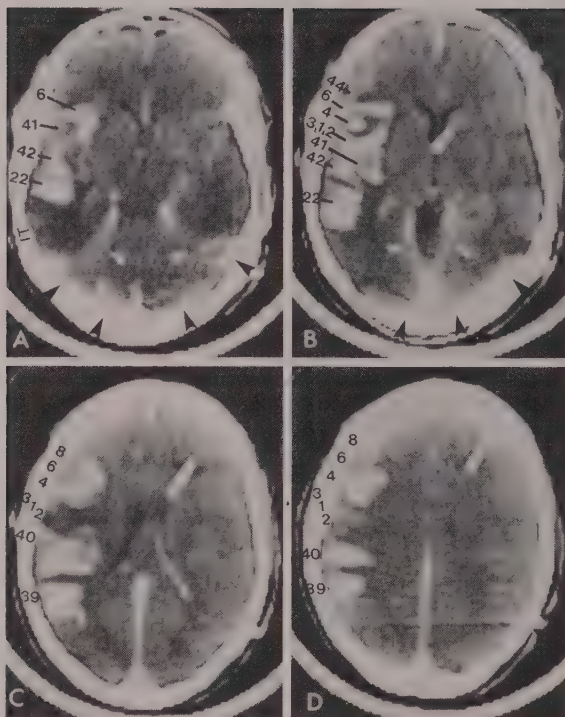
Infarction of the left cerebrum. CT localization to specific Brodmann areas. CECT scans in a 40 year old woman with severe left middle cerebral artery spasm and prolongation of the left arteriovenous circulation time to 10.0 seconds after subarachnoid hemorrhage, clipping of a left posterior communicating artery aneurysm, and insertion of a ventriculoperitoneal shunt for hydrocephalus. The gyral blush associated with the cerebral ischemia delineates the gyral anatomy corresponding to the Brodmann areas (see Figs. 2B and 3). A, CECT scan along reference line 3 reveals gyral contrast enhancement in Brodmann areas 6, 41, 42, and 22 with edema involving the inferior temporal gyrus (IT). Brodmann areas 10, 46, 45, and 44 are spared at this level. The white arrowheads indicate the tentorial blush and the black arrowheads the transverse dural sinuses which should not be mistaken for gyral blush. B, CECT scan along reference line 4 reveals gyral contrast enhancement in Brodmann areas 44, 6, 4, 3, 1, 2, 41, 42, and 22 (white and black arrowheads as in A). C, CECT scan along reference line 6 reveals gyral blush in Brodmann areas 8, 6, 4, 40, and 39. Areas 3, 1, and 2 appear to be spared at this level. D, CECT scan along reference line 7 reveals gyral blush in Brodmann areas 8, 6, 4, 40, and 39, but not 3, 1, and 2.
